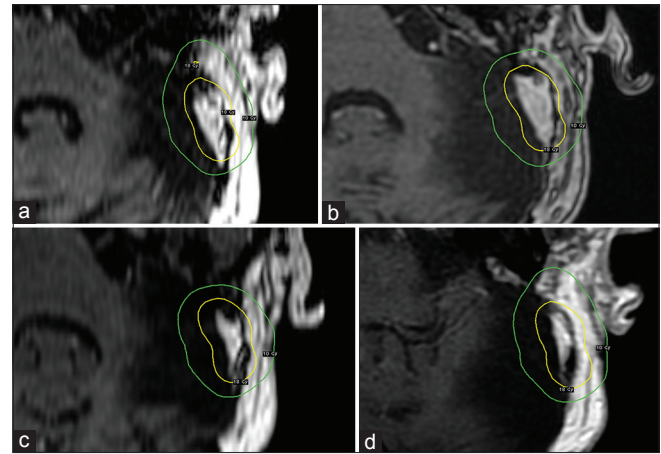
(a–d) MRI of the tumor; (a) Pre GKRS MRI, October 2014. Tumor volume 4.43 cm³. (b) Stereotactic (Treatment) MRI, Feb. 2015. Tumor volume 5.15 cm³. (c) Post GKRS MRI at 12 months, Feb 2016. Tumor volume 3.87 cm³. (d) Post GKRS MRI at 20 months, Nov 2016. Tumor volume 1.69 cm³
